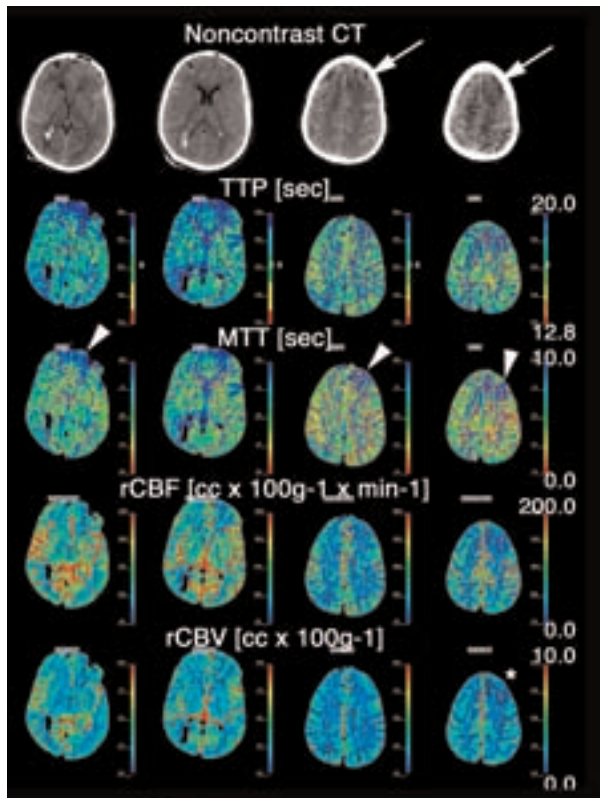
Patient transferred at day 8 to our neurovascular ICU from outside institution after coiling of ruptured anterior communicating artery aneurysm. Noncontrast CT obtained at admission of patient in ICU demonstrates extensive residual subarachnoid hemorrhage and suspicious loss of gray-white matter contrast in left superior frontal gyrus (white arrows). Tip of right ventricular drain catheter is also visible. On perfusion CT (PCT), significantly abnormal brain perfusion in distribution of anterior and inferior branches of left (also, to a lesser extent, right) anterior cerebral arteries (ACA, arrowheads) and of right posterior middle cerebral artery (MCA) branches is seen primarily on MTT and TTP (time to peak) maps. The rCBF was also slightly decreased in the same territories, whereas rCBV was mainly preserved (it is lowered only in left superior frontal gyrus, star). CT angiography confirmed suspicion of moderate vasospasm of both A2 and A3 segments of ACA (arrows), ultimately verified by gold standard DSA. No abnormality of right posterior MCA branches was identified. Artifacts created by coils on CTA images obscure A1 segments bilaterally and interfere with their evaluation. Endovascular therapy (IA verapamil) was performed in ACA territories during DSA.
